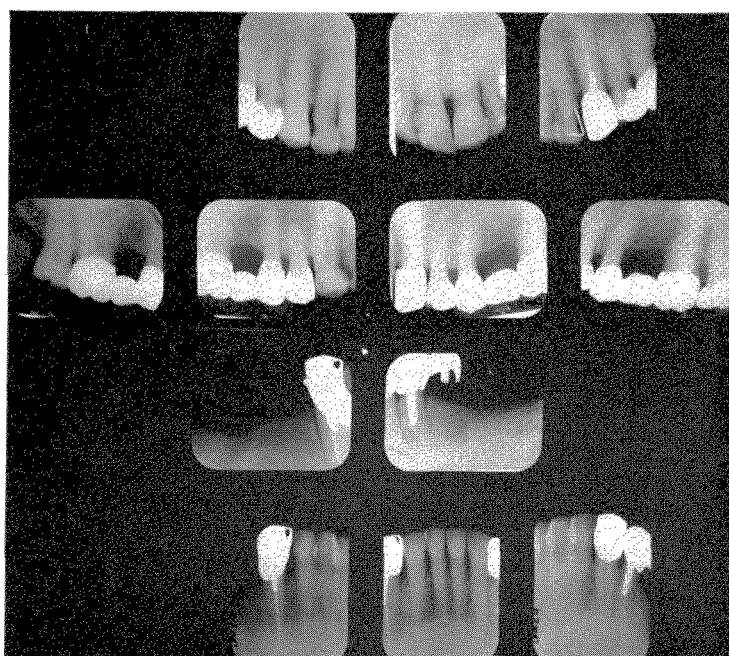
Roentgenograms taken in 1961 after the removal of the lower right molar root.
